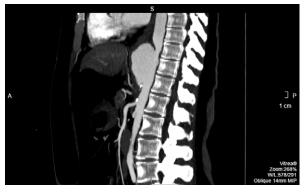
Preoperative computed tomographic scan (lateral view) shows the saccular aneurysm originating from the thoracoabdominal aorta (necessitating extent III repair). The aneurysm extends to the occluded celiac artery.
